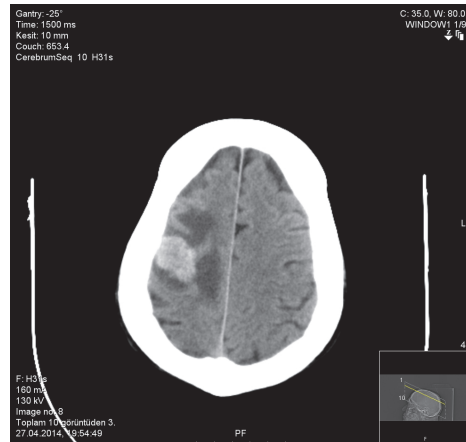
CT image of the patient developing brain metastases.
